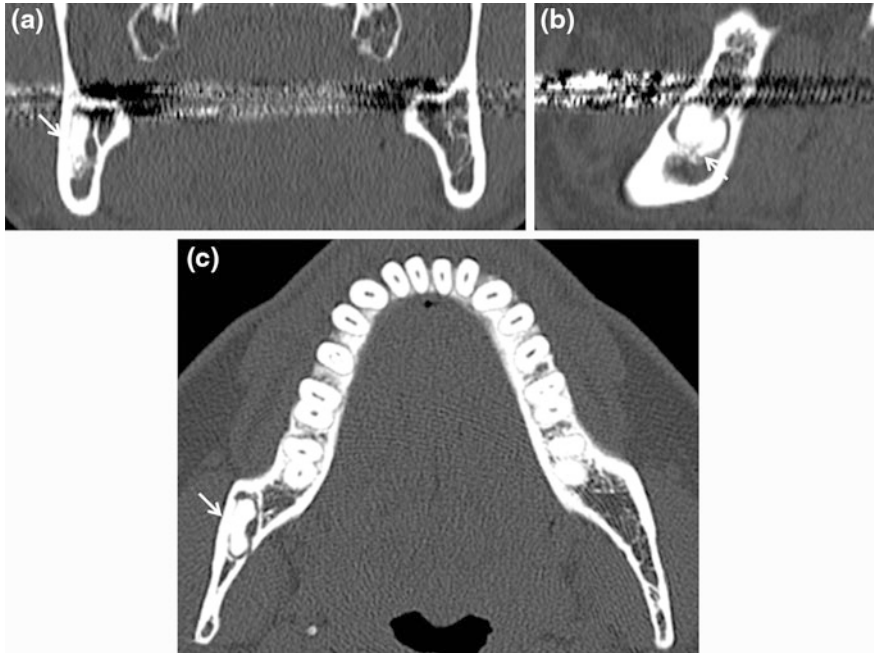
CBCT coronal (a), sagittal (b) and axial (c) sections showing well-defined radiopaque lesion (*thin arrow*) in the posterior branch of the mandible. The lesion is surrounded by radiolucent band and radiopaque cortex giving it a target appearance. There are no signs of root resorption and of invasion of mandibular canal. The radiographic signs suggest a benign process and are consistent with complex odontoma
